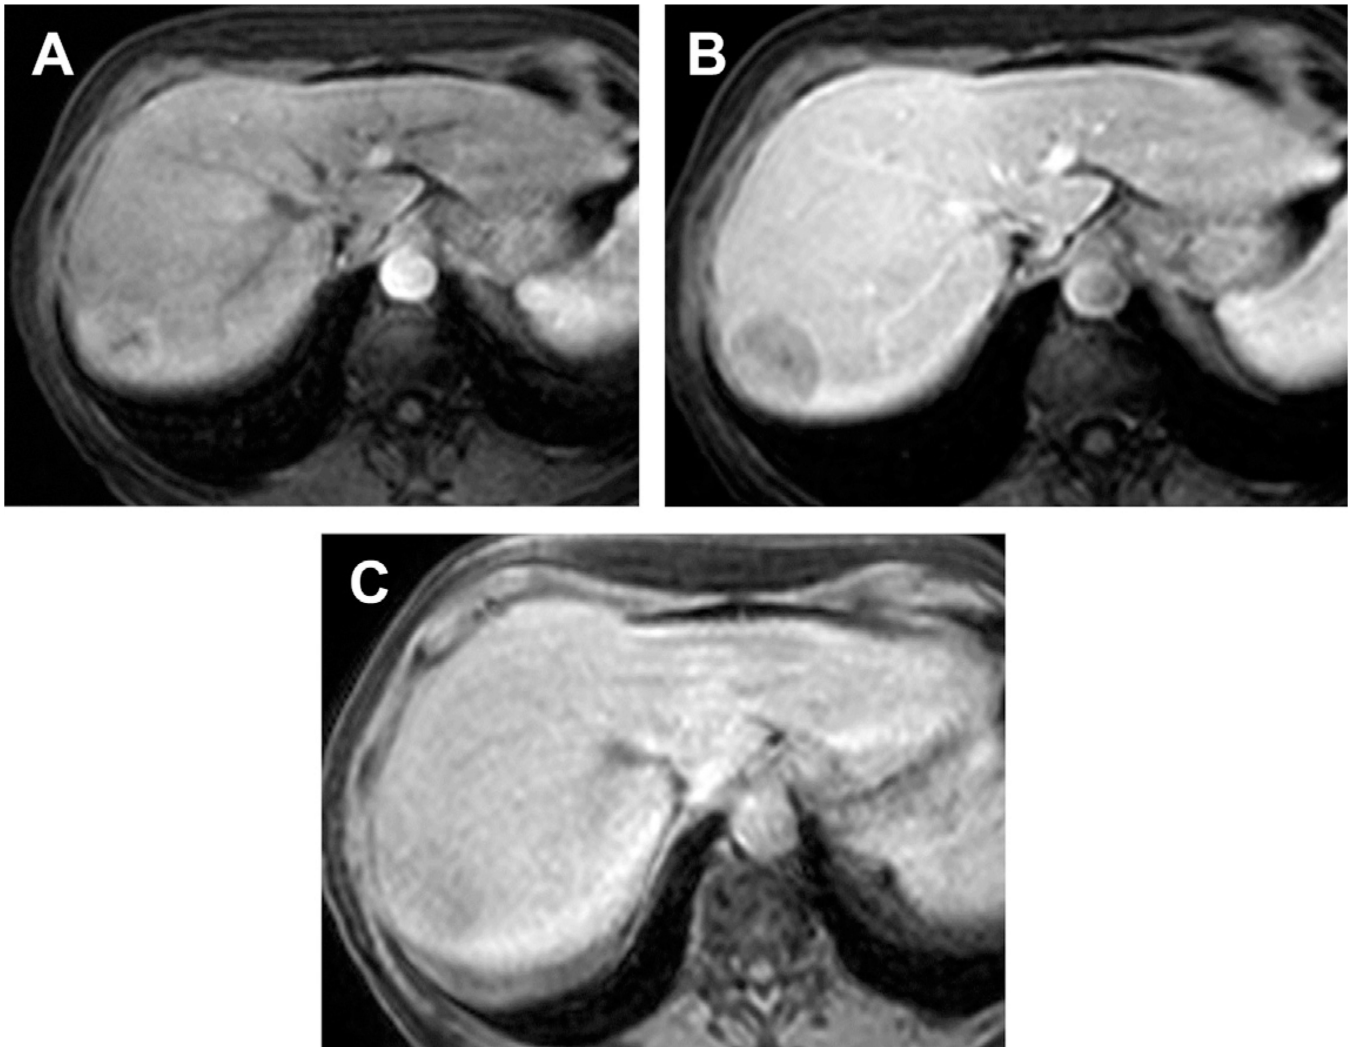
Well-differentiated HCC with Gd-BOPTA. (A, B) DCE-MR imaging during arterial and venous phases demonstrates a nodule with homogeneous enhancement on arterial phase and delayed washout (C) The nodule is slightly hypointense to liver parenchyma during the HB phase.
